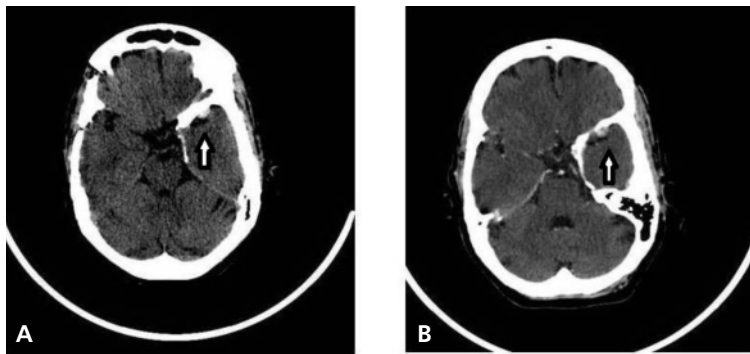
CT scan of brain, showing meningioma with intralesional calcifications in the scan without contrast (A), becoming hyperdense after contrast administration (B).
